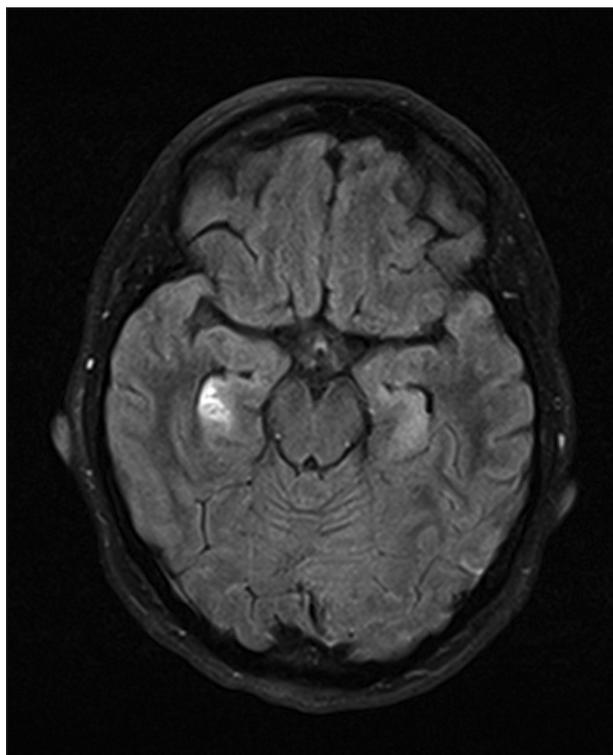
Extrapontine demyelination in corpus callosum, limbic lobes of parahippocampal gyrus and hippocampus (MRI T2 dark fluid)
